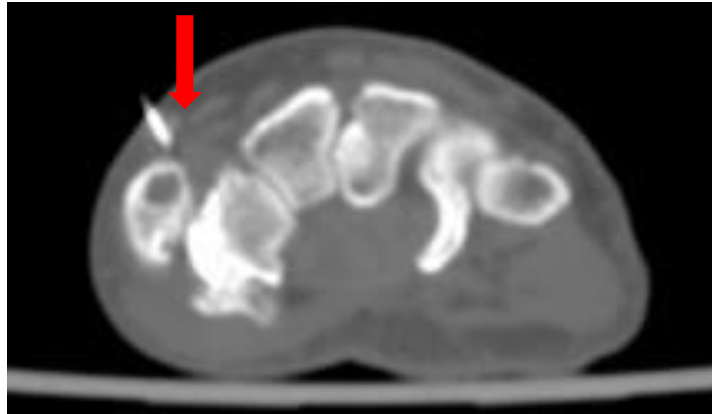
Preliminary CT scan: checking the positioning of the 25G needle (arrow).
